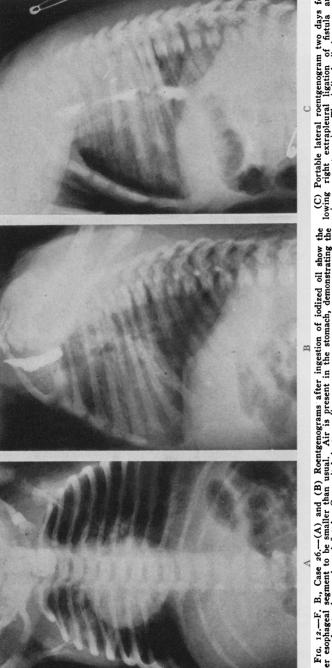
F. B., Case 26.—(A) and (B) Roentgenograms after ingestion of iodized oil show the upper esophageal segment to be smaller than usual. Air is present in the stomach, demonstrating the presence of a tracheoesophageal fistula. Congenital dextrocardia.
